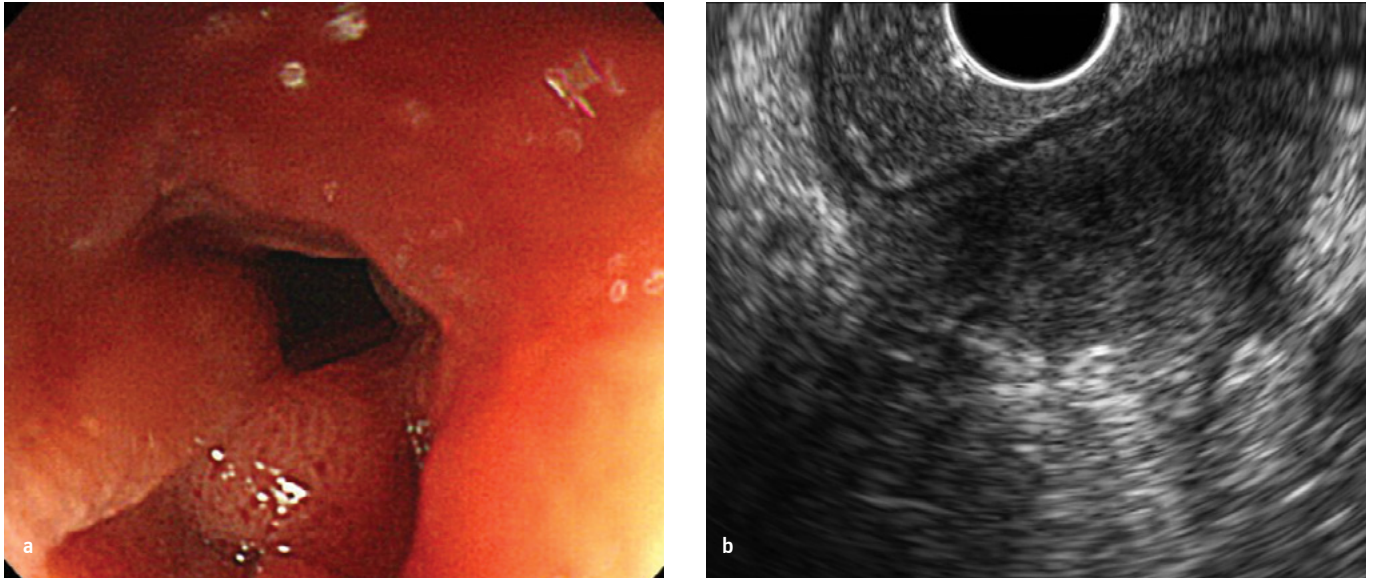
a, b. Endoscopic images. Upper endoscopy showed swelling and redness of the mucosa (a), endoscopic ultrasonography showed a homogeneous low echoic lesion located in the subserosal layer (b)
